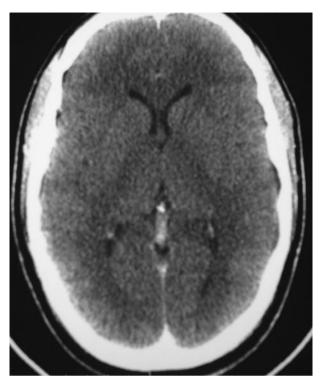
Cerebral CT scan showing disappearance of cortical sulci with collapse of ventricles.
